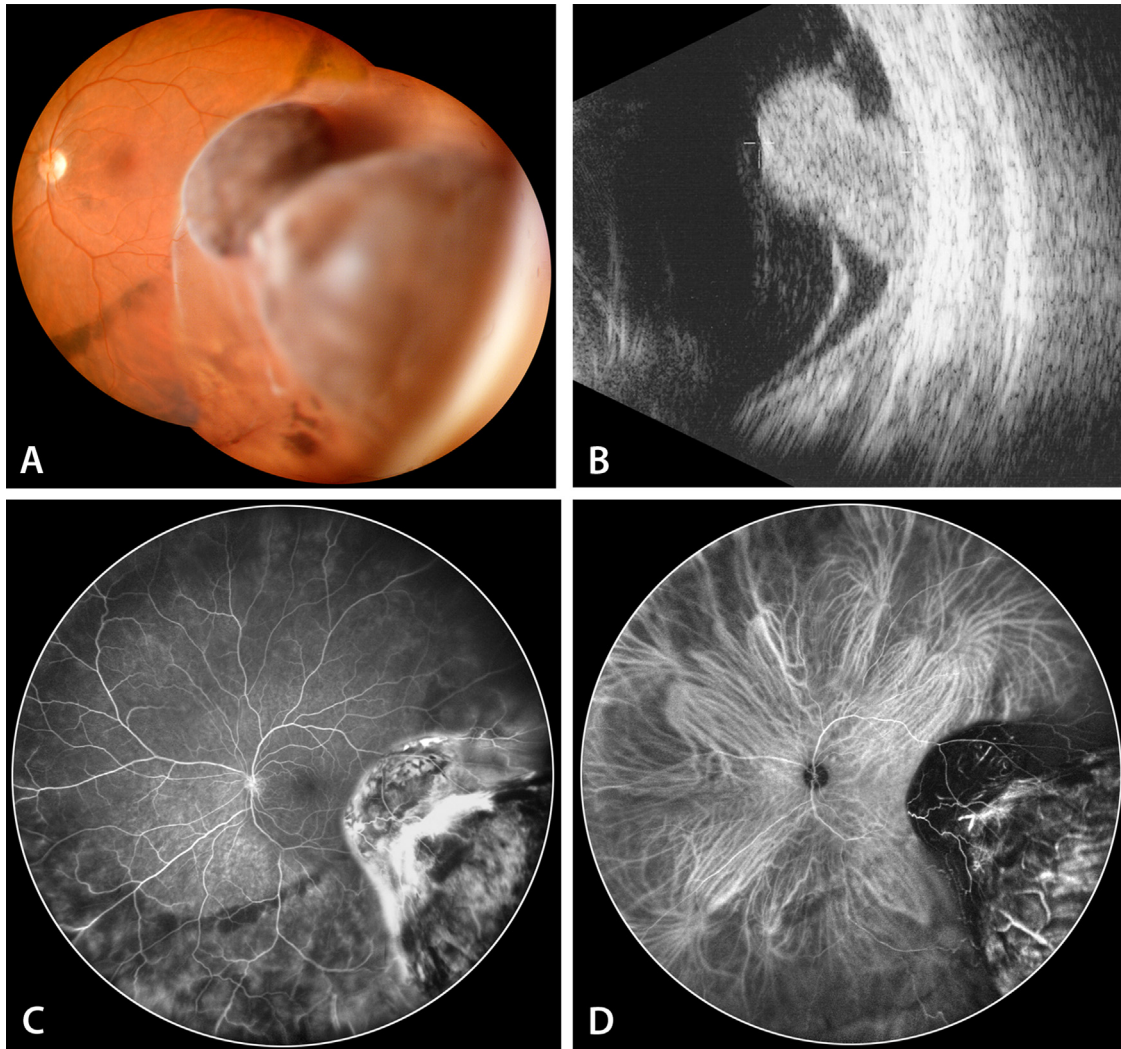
Large mushroom-shaped choroidal melanoma. (A) Composed color fundus photography (Panoret-1000, CMT Medical Technologies Inc., Valley Stream, NY) of a pigmented mass rising from the peripheral temporal inferior choroid in a 54-year-old male, complaining of a progressive nasal superior scotoma. VA = 1.0. An associated semicircular watershed line of subretinal pigment dispersion can be observed. (B) On 10 MHz B-scan ultrasonography, the tumor is mushroom shaped and complicated by an extensive retinal detachment. $H = 8.7$ mm. (C) On panoramic FA (Heidelberg Engineering spectralis widefield imaging using a staurenghi 150-degree contact lens), the mass presents an increasing hyperfluorescent diffusion from its surface. Signs of ischemia can be seen within the secondary inferior retinal detachment, even before radiation therapy. In consequence, intravitreal anti-VEGFs are also initiated, to avoid neovascular complications.²⁴ (D) On panoramic ICG-A (Heidelberg Engineering spectralis widefield imaging using a staurenghi 150-degree contact lens), the hypocyanescent mass presents a dilatation of its intratumoral vessels, and the associated inferior retinal detachment provokes a masking defect of the underlying choroidal vascularization, caused by an increased density of the subretinal fluid. FA, fluorescein angiography; H , height; ICG-A, indocyanine green angiography; VA, visual acuity; VEGF, vascular endothelial growth factor. *Courtesy of Dr A Schalenbourg.*
